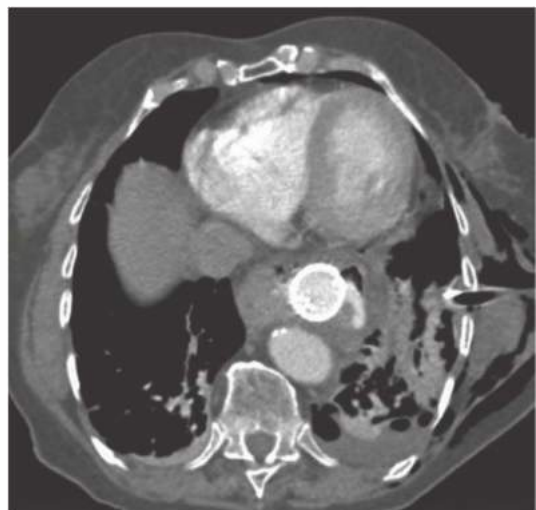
• CT scan with extraluminal leak of water-soluble oral contrast in the mediastinum. Subcutaneous emphysema is also present.
